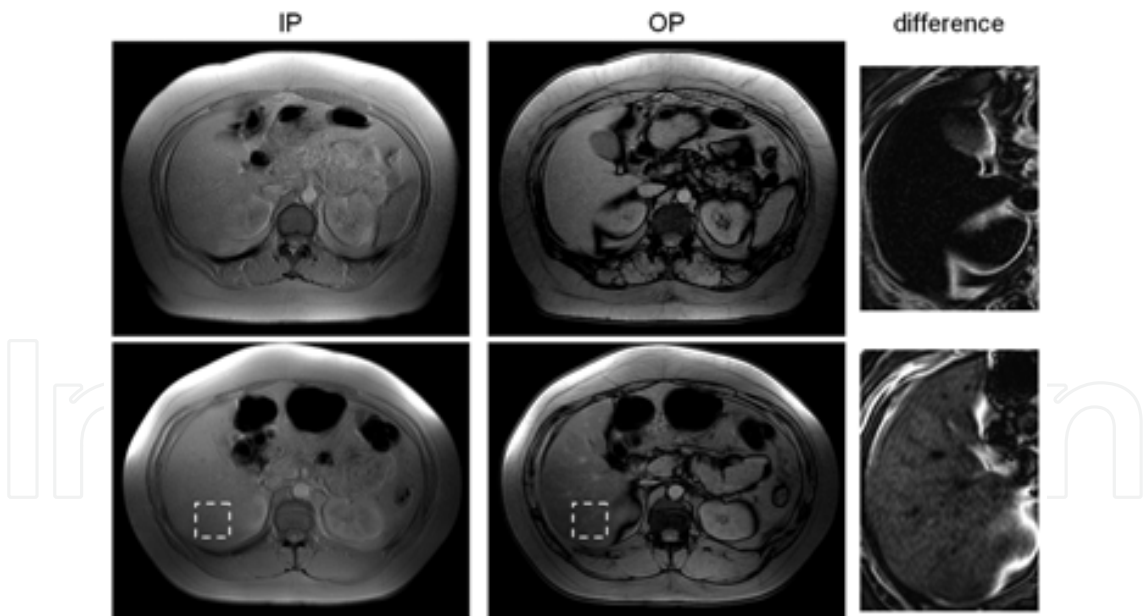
Two-point Dixon MRI. In-phase (IP) and out-of-phase (OP) images from two subjects are shown. In the first subject (top row), the signal intensities within the liver between IP and OP images are similar. This signifies very little presence of hepatic fat. In the second subject (bottom row), the liver signal intensities is lower in the OP image (dashed regions). This indicates presence of hepatic fat. The difference image of the top subject is nearly zero in the liver, whereas the lower subject shows appreciable signal. As determined by MRS, the hepatic fat fractions of the subjects were 3.4% and 21.2%, respectively.
